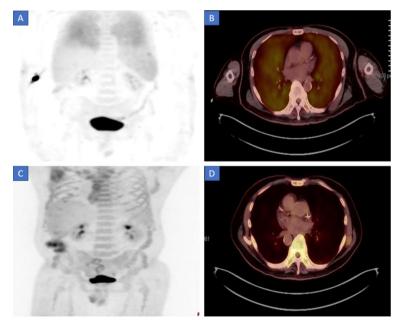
A&B: PET/CT scan shows mild FDG activity in both lungs (SUV=2.2), C&D: PER/CT scan shows no FDG activity after competing 2 cycles of MATRIX chemotherapy
